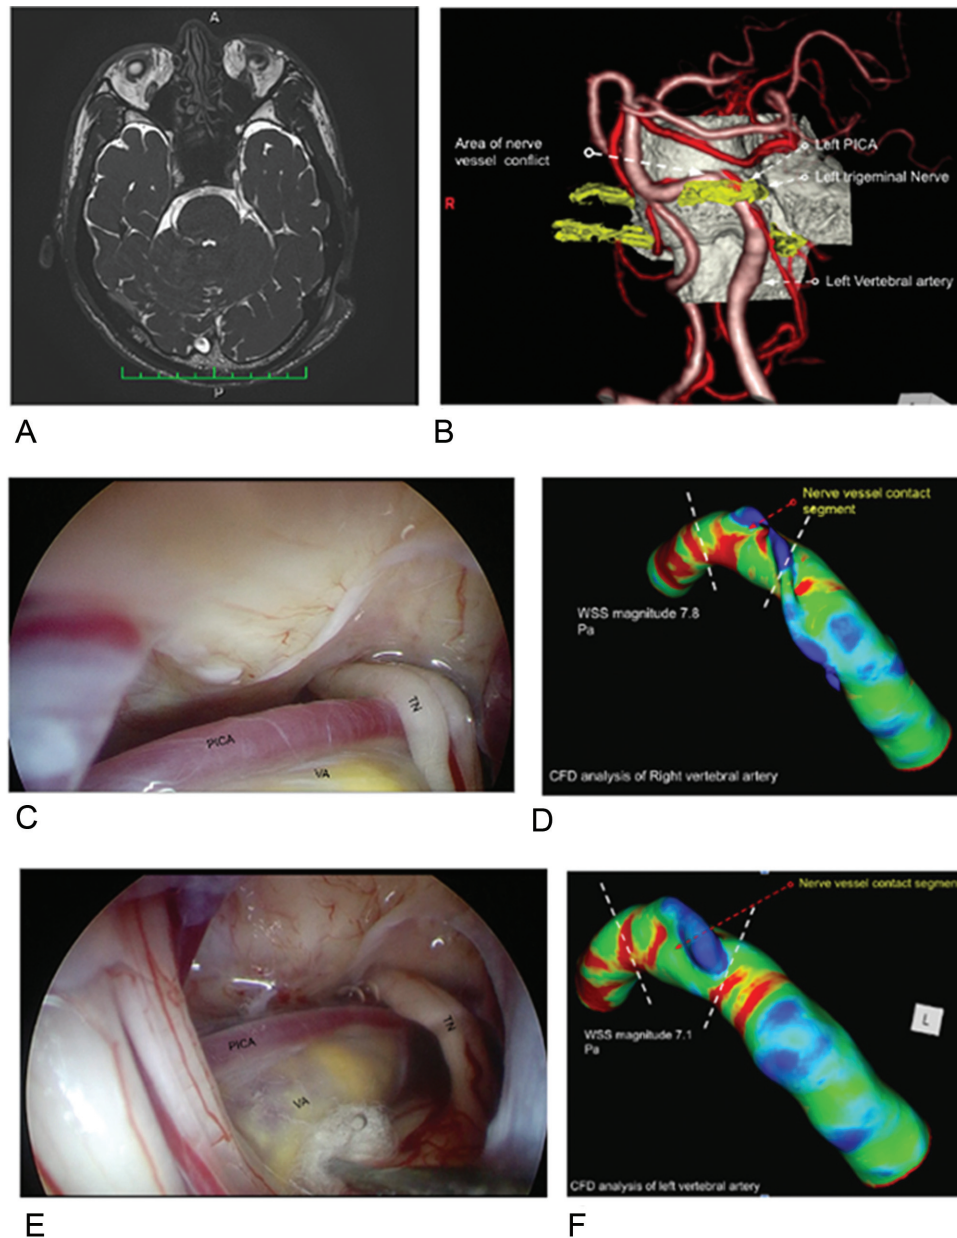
(A) Magnetic resonance imaging (MRI) cisternogram showing right trigeminal nerve and vertebral artery nerve vessel contact. (B) Computed tomography angiography (CTA) and MRI cisternogram fusion image showing neurovascular contact of the trigeminal nerve and vertebral artery (VA), superior cerebellar artery (SCA), and posterior inferior cerebellar artery (PICA). (C,E) Intraoperative endoscopic view before and after decompression. (D,F) Computational fluid dynamics (CFD) analysis before and after decompression. TN, trigeminal neuralgia; WSS, wall shear stress.
